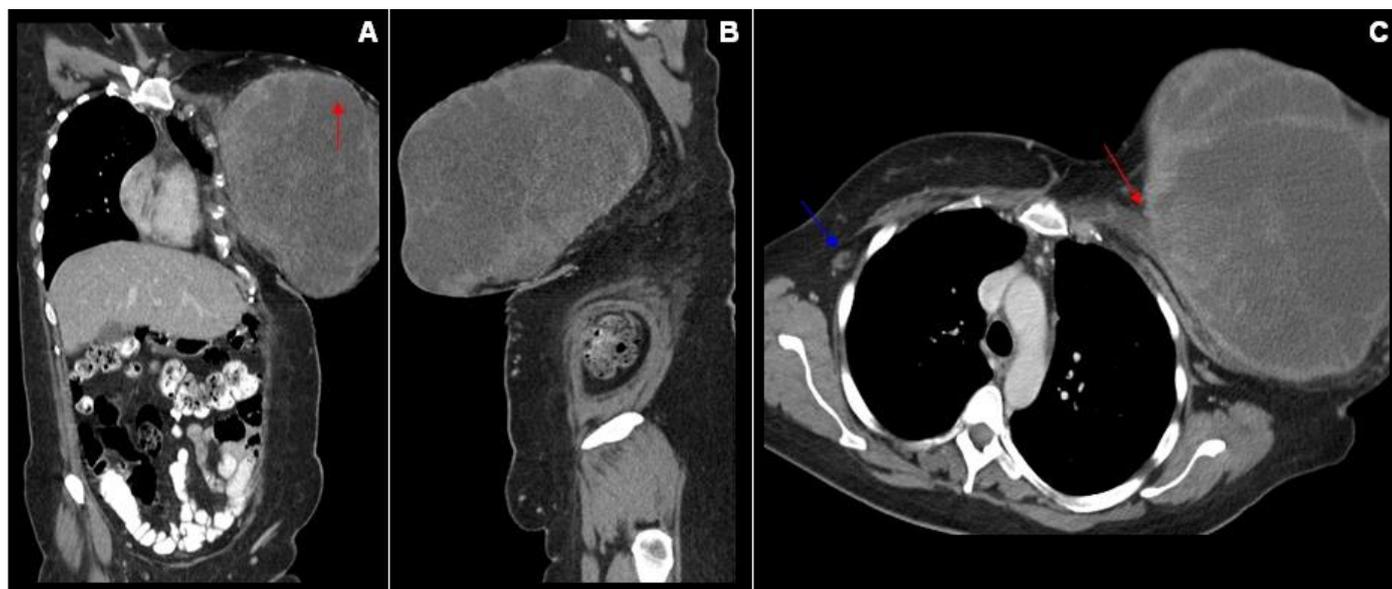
43 year old female with malignant phyllodes tumor. Contrast enhanced CT of the chest, abdomen and pelvis. 410 mAs, 120 kVP, 1.5 and 5.0 millimeter (mm) slices.
